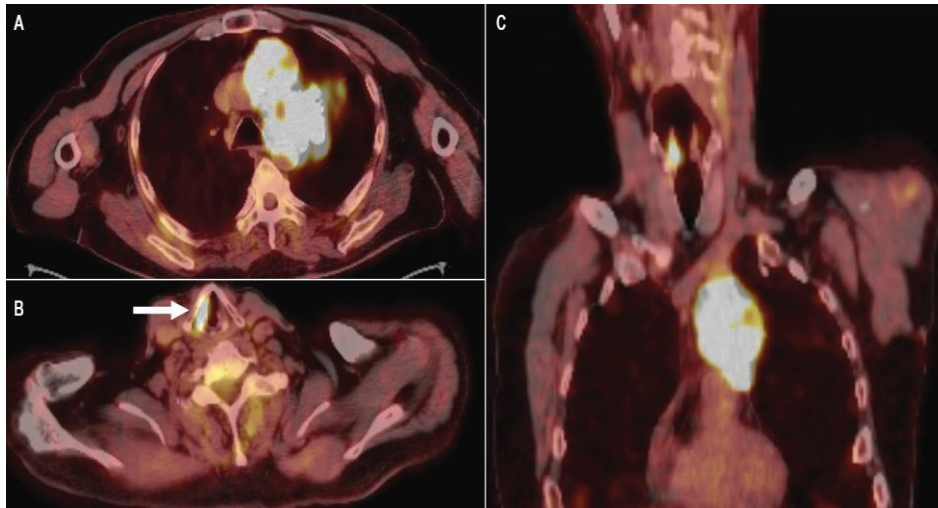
PET/CT of the patient showing an FDG-avid mass in the left upper lobe (panel A), and an asymmetric FDG uptake within the right vocal fold (panels B and C).
